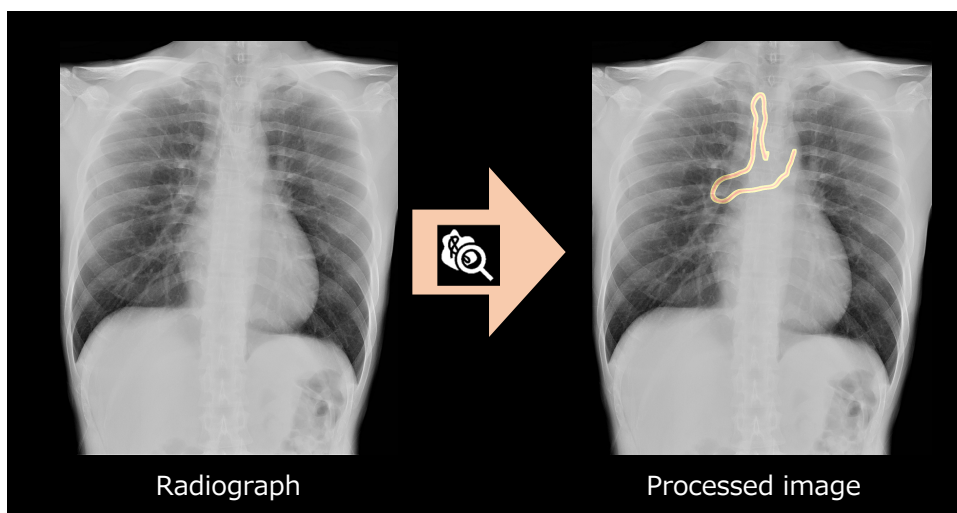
Chest Radiograph and Image Processed by Smart DSI
